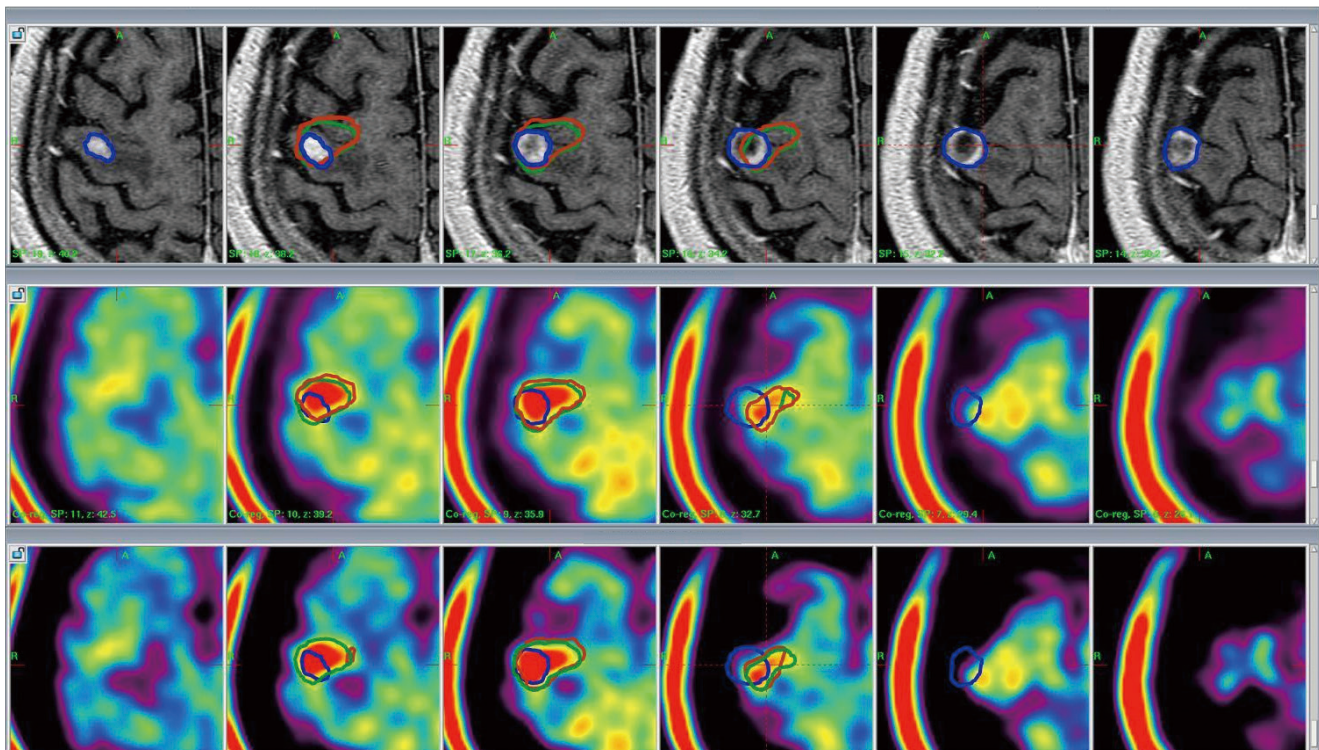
MET-PET/CT and MET-PET/MR fusion images with the Leksell GammaPlan®. Upper : MR-enhanced images; MR-enhanced volume (blue line), 1.26 cm³. Middle : MET-PET/CT fusion images; metabolic tumor volume (brown line), 1.41 cm³; matching percentage, 25.5%. Lower : MET-PET/MR fusion images; metabolic tumor volume, 1.41 cm³ (green line); matching percentage, 25.0%. Matching volume : MTV including the MR-enhanced volume; matching percentage (%) : (matching volume/total MTV)×100. MET-PET : ¹¹C-methionine positron emission tomography, CT : computed tomography, MR : magnetic resonance, MTV : metabolic tumor volume.
